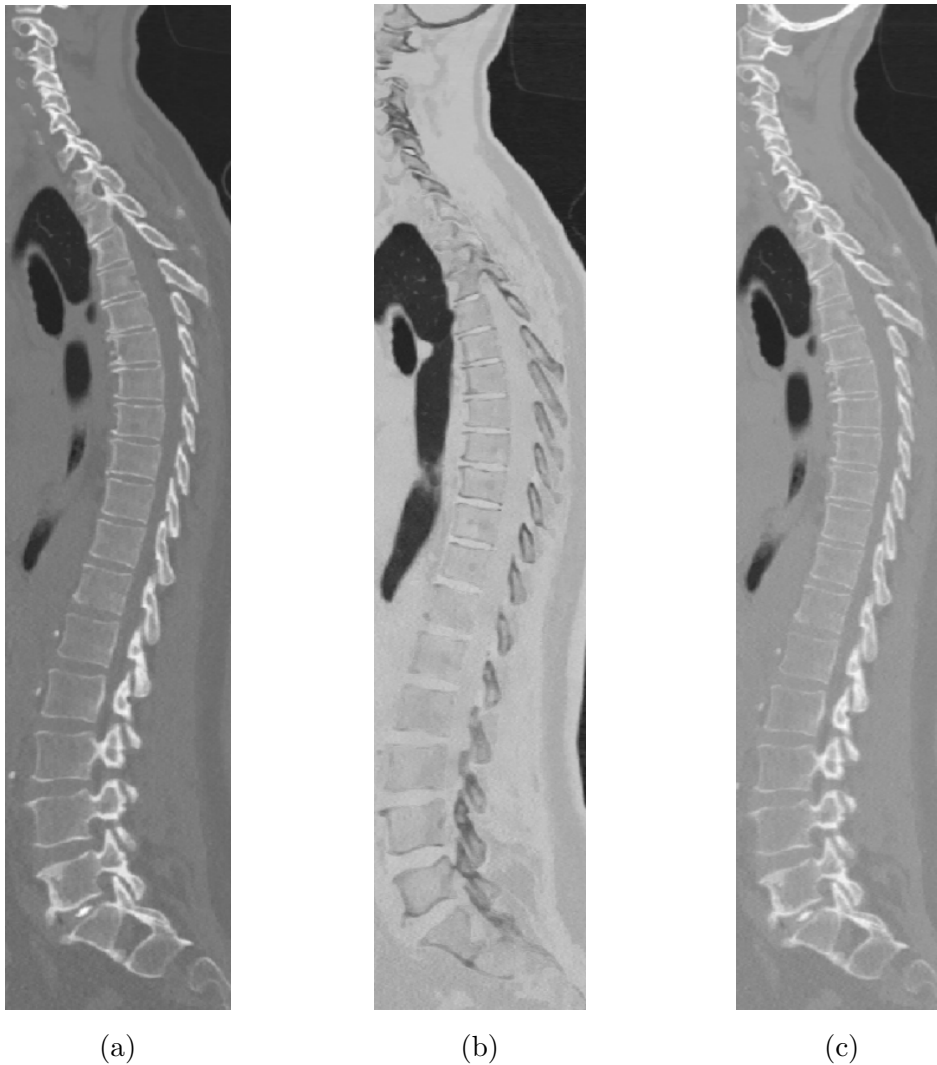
Example of parametrical images, MM patient, (a) - conventional CT, (b) - 50 % calcium suppression, (c) - virtual monoenergetic image at 120 keV.
